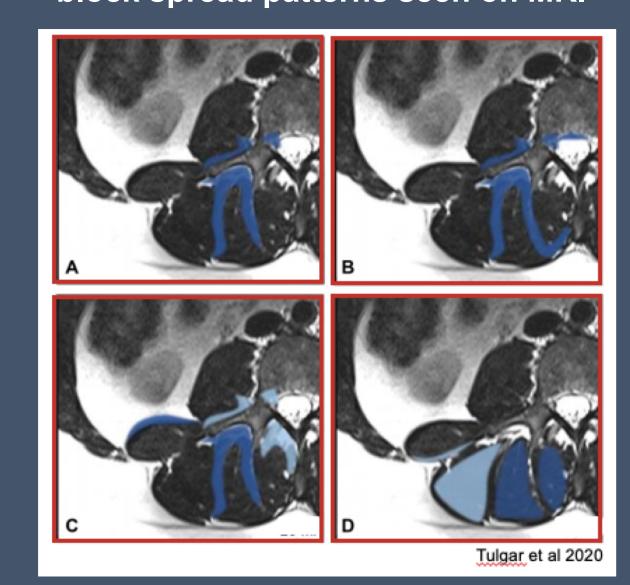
Tulgar et al study of ESP block spread patterns seen on MRI
